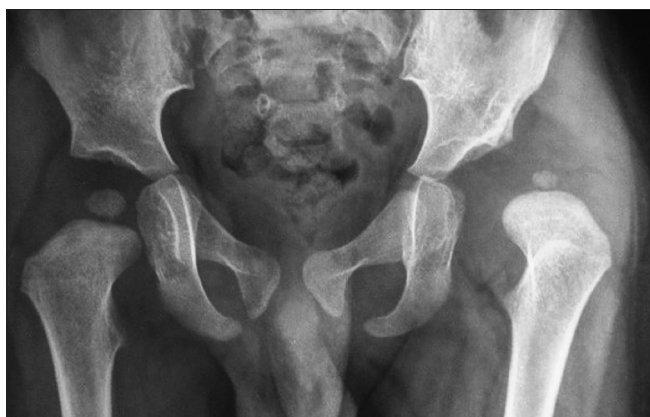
The child underwent open reduction and spica application. X-ray pelvis with both hip joints anteroposterior view showing redislocation of the hip 6 months after spica removal
